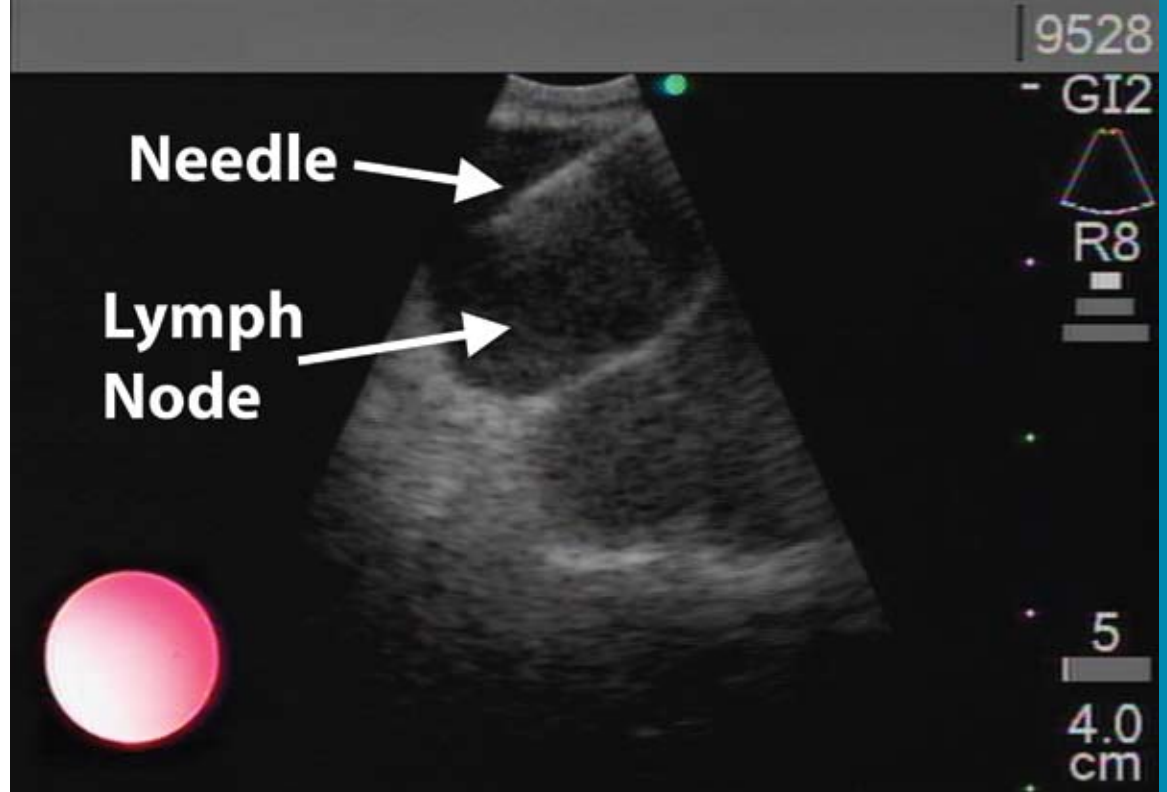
Endobronchial ultrasound and needle biopsy of a mediastinal lymph node being performed at OHSU.
